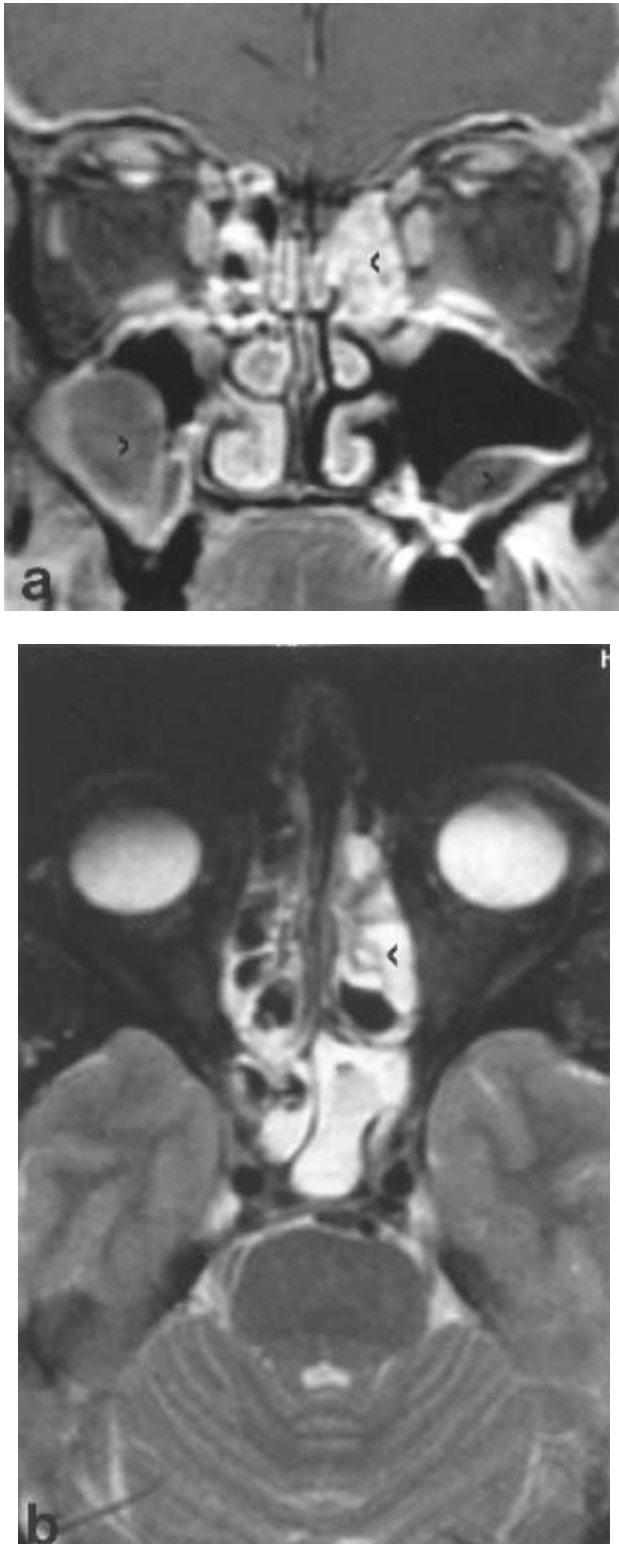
T1-weighted coronal MR scan (a) after administration of Gd-DTPA shows highly enhanced lesion in the left ethmoid air cells (arrow). On the T2-weighted axial scan (b) the lesion is relatively hyperintense (arrow) which together with enhancement pattern is suggestive of inflammatory mucosal tissue. The T1-weighted scan (a) also demonstrates two hypointense cystic lesions in both maxillary sinuses (arrows).
